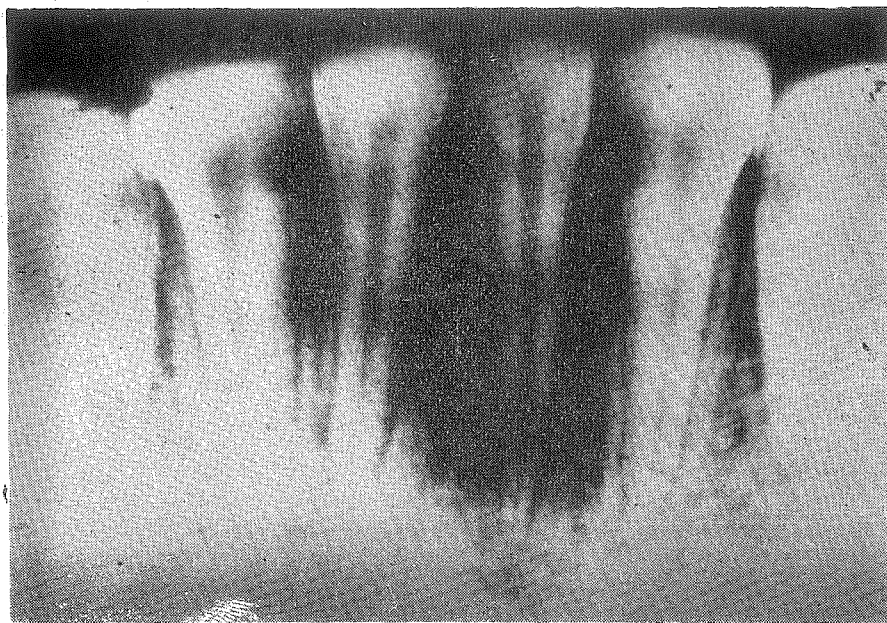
X-ray of the lower jaw incisor and lateral prior to canal therapy. The right lateral incisor clearly shows the existence of a diffuse process in the apex.
